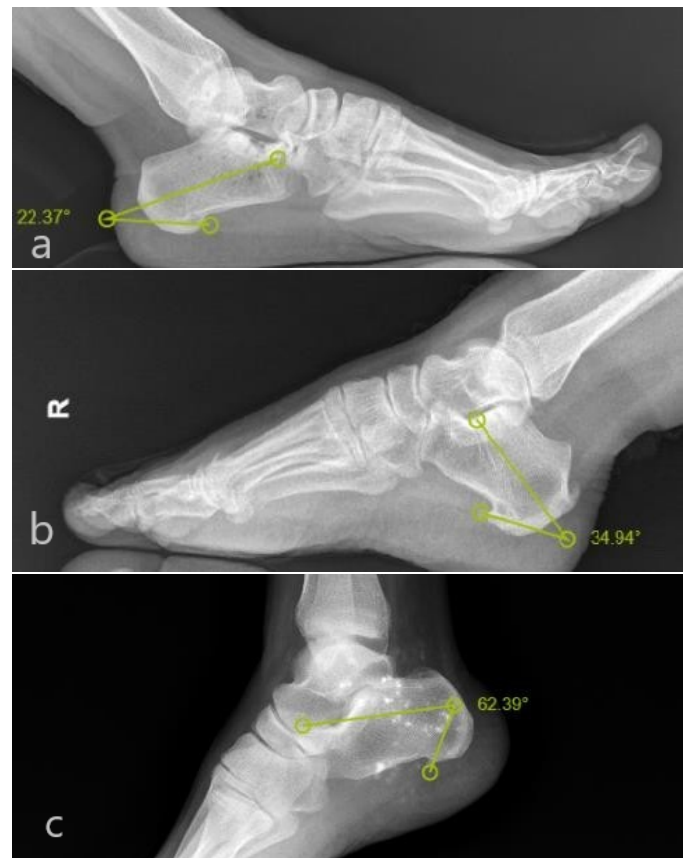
X-rays of classification of plantar calcaneal spurs. Type I, angle was less than 30° (a). Type II, angle was from 30° to 60° (b). Type III, angle was more than 60° (c).
